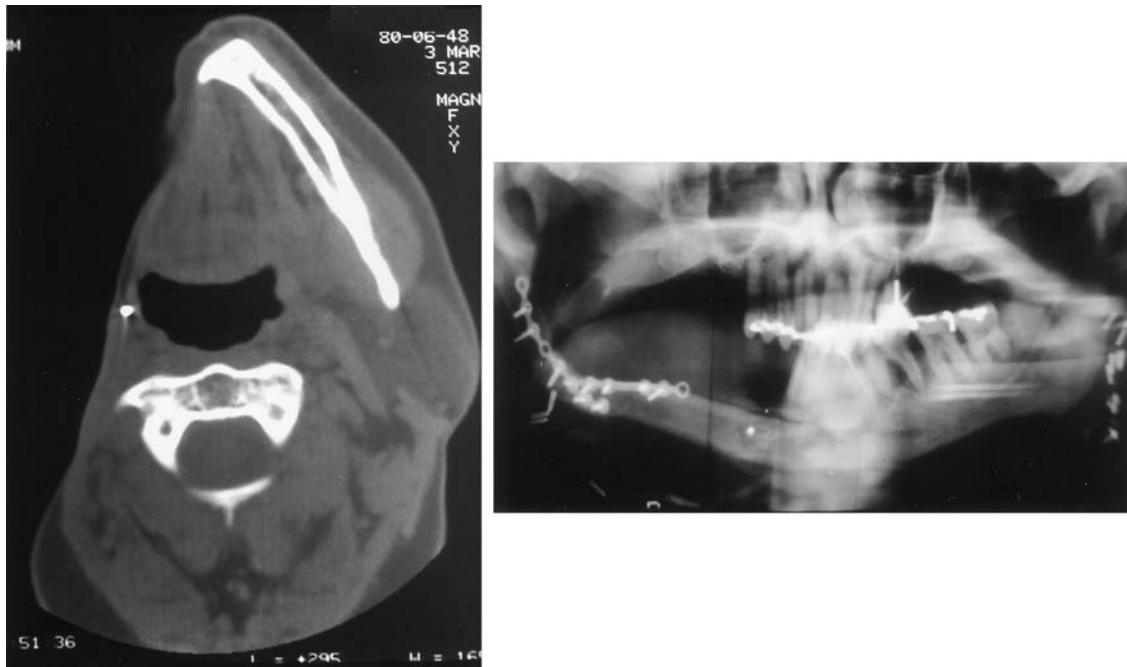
(Left) Preoperative computed tomographic scan of patient from Figure 7 shows extent of original tissue defect. (Right) Panorex radiograph at long-term follow-up. Note the symmetric contour of the inferior border of the mandible, the primary determinant of lower facial symmetry restoration.
